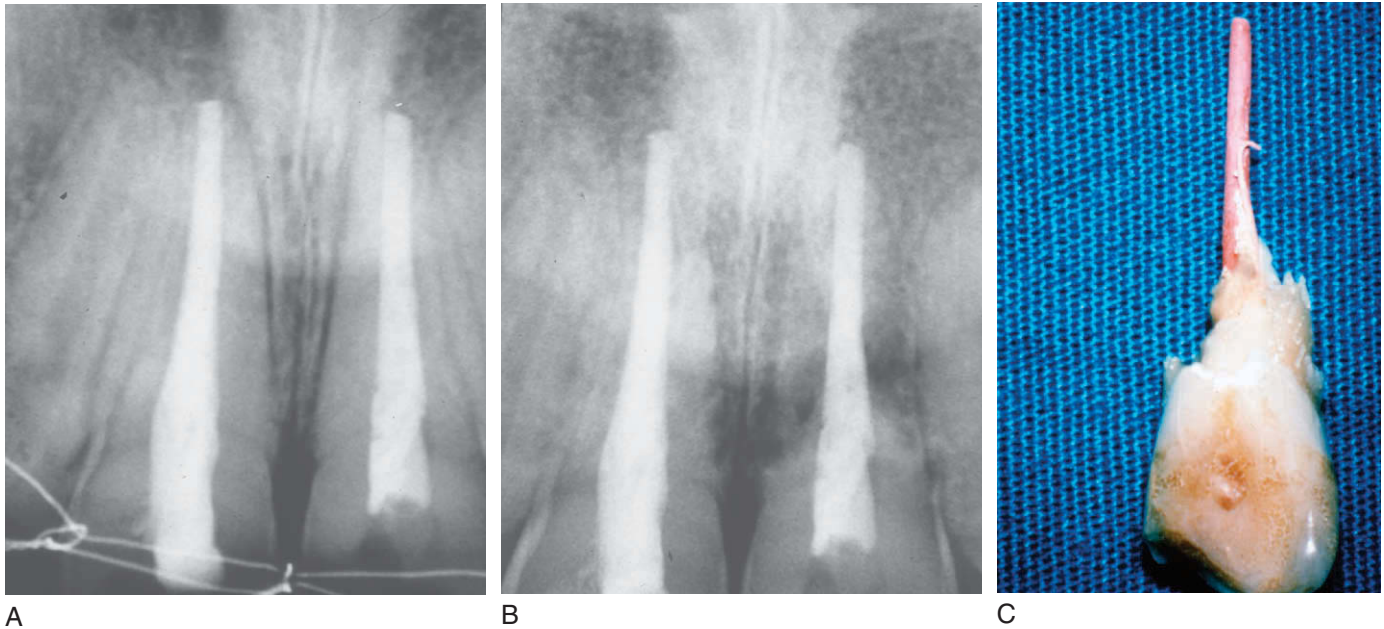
A, Avulsed and replanted tooth as seen just after trauma and endodontic treatment and subsequent radiograph 6 months later (B) revealing extensive resorption. C, Following extraction, virtually all that remained was gutta percha.
